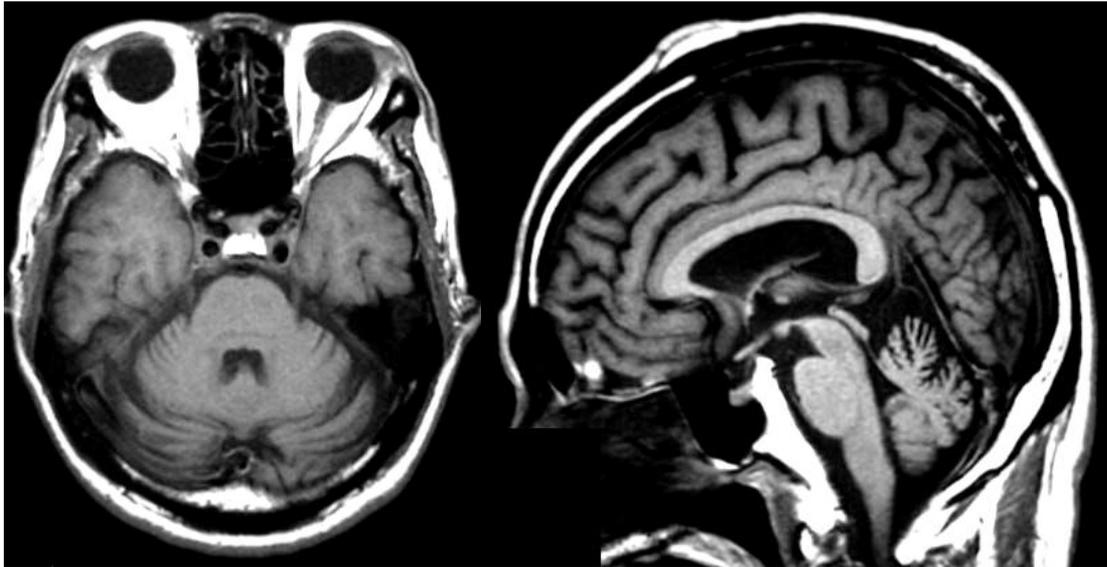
Brain MRI of the representative case. Axial and sagittal views of T1-wegted images show marked cerebellar atrophy.
